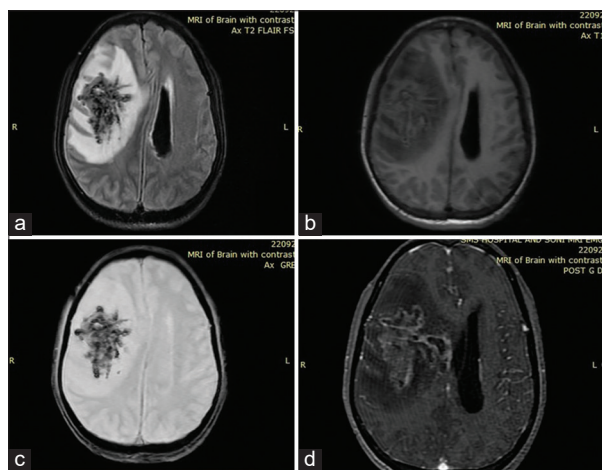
(a-d) Magnetic resonance imaging brain showing T2 hyperintense lesion in right temporal and occipital lobes (a), Surrounding edema with effacement of basal cisterns midline shift to left (a-d), Patchy diffusion restriction, gradient-recalled echo blooming (c), Irregular peripheral enhancement with hemorrhagic component (a-d)
